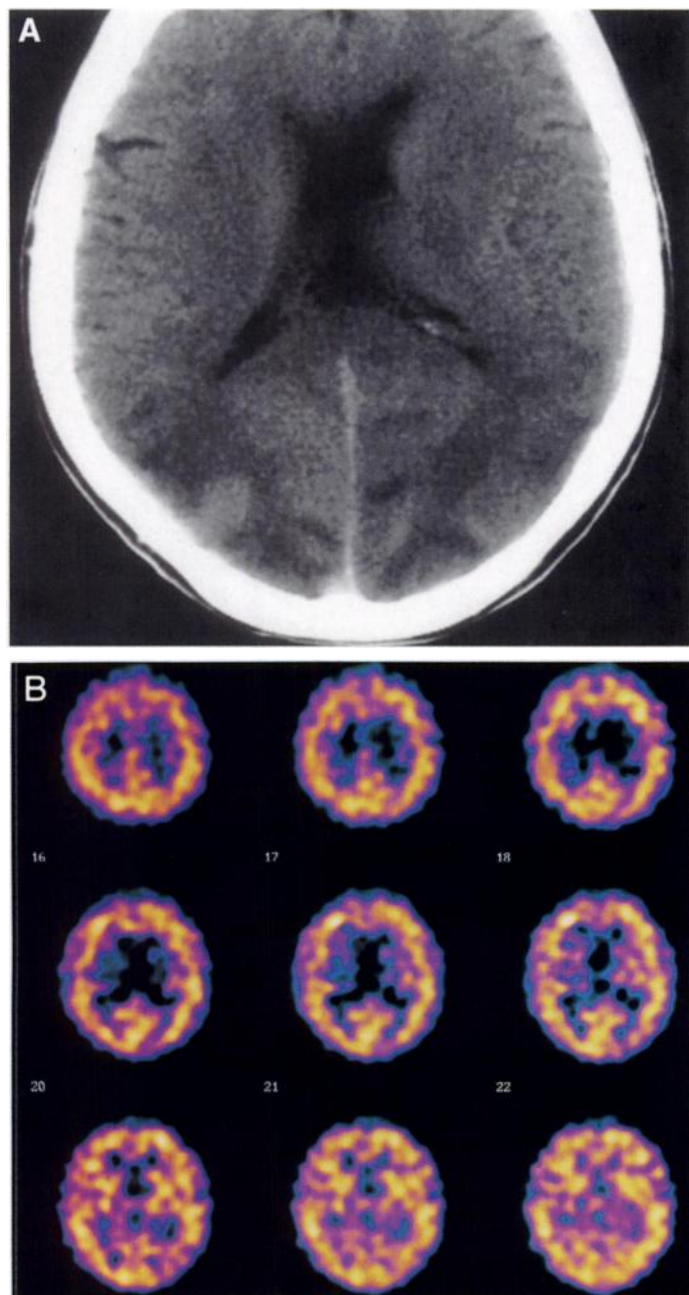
(A) Noncontrast CT shows symmetrical low density in the white matter of the parieto-occipital regions bilaterally. (B) Representative transaxial slices from the initial ^{99m}Tc -HMPAO SPECT performed 4 days later show moderately and symmetrically reduced perfusion to both parieto-occipital lobes.
